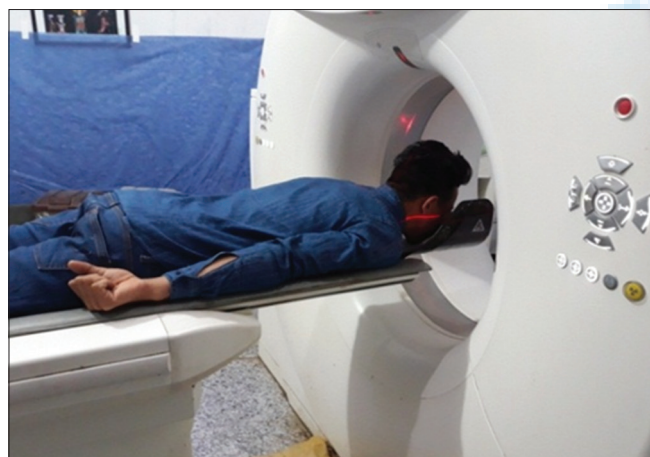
Positioning of a patient in computed tomography. Device for coronal imaging of paranasal sinuses
